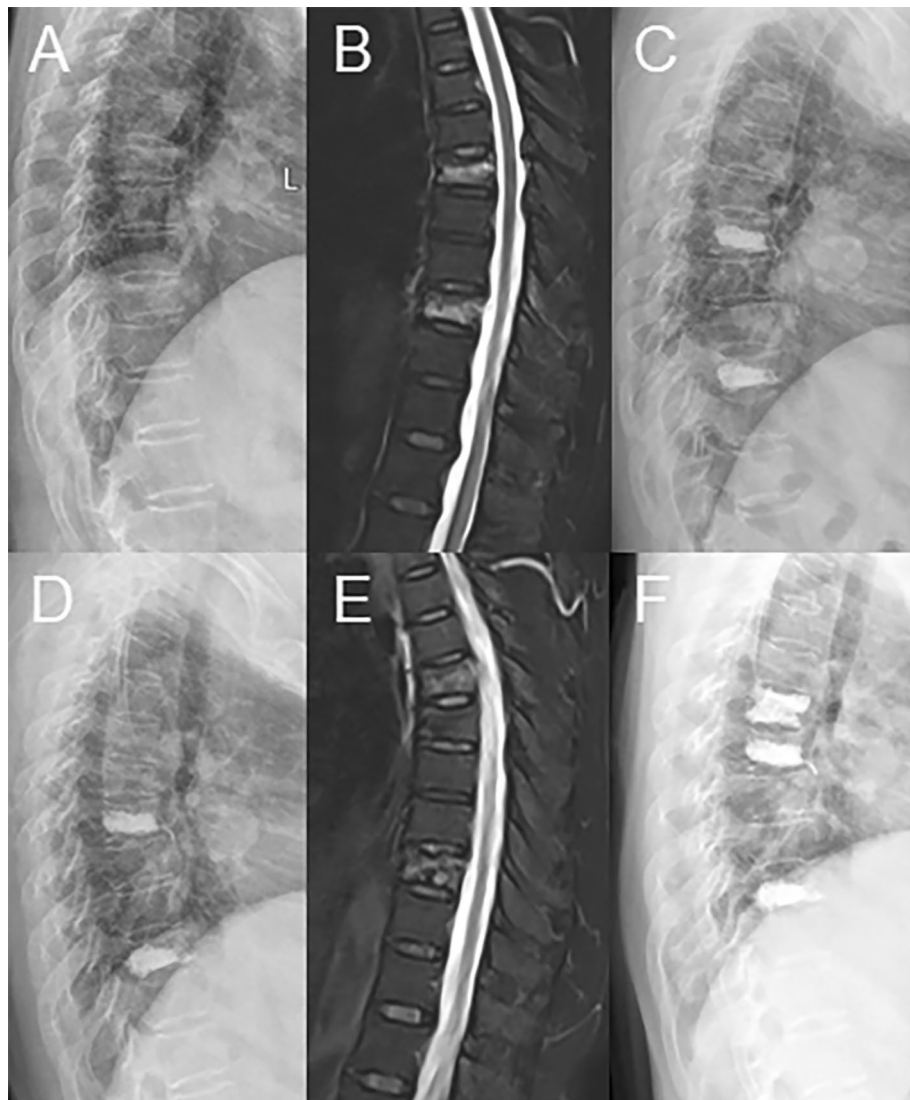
A representative case of AVF following PVP (A–F). (A,B) X-ray and MR images showing fractured T7 and T10 vertebrae in a 60-year-old female. (C) X-ray revealing that the fractured T7 and T10 vertebrae were treated. (D,E) X-ray and MR images indicating that the T6 vertebrae fractured three months after surgery. (F) X-ray demonstrating that the fractured T6 vertebrae was treated again.
